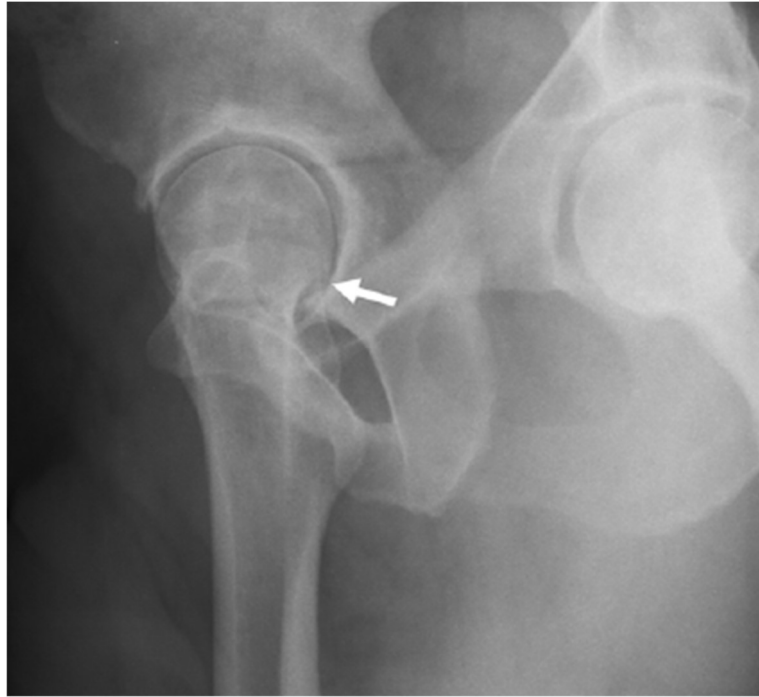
CT scan of hip joint without the aid of radiopaque solution (Tannast et al., 2007). It was difficult to differentiate acetabular cartilage and femoral cartilage at the contact region (arrow).
